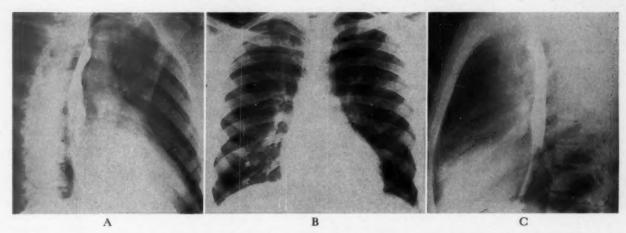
Case 15. Roentgenograms in right anterior oblique (A), posteroanterior (B) and left anterior oblique (C) positions indicating some slight increase in pulmonary vascularity, no cardiac chamber enlargement and slight prominence of the pulmonary artery segment chiefly in the right anterior oblique position.
